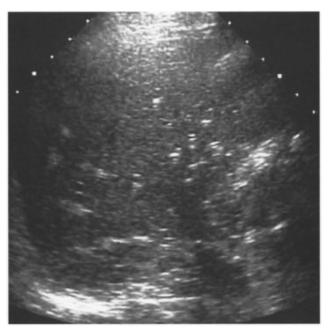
In ultrasound, a finding like this is typical, showing numerable small calcifications in the liver.
